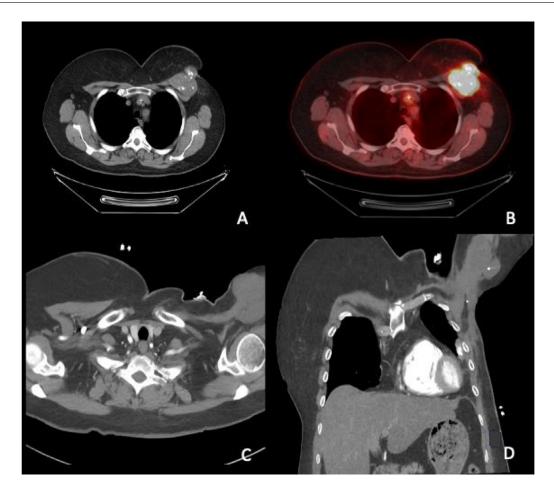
Initial staging PET/CT with upper outer MBC and subsequent CT chest with recurrent left axillary MBC after mastectomy. Initial staging PET/CT in the axial plane demonstrates avid FDG uptake of the upper outer left breast mass with tissue diagnosis of MBC (A, B). Five months after left mastectomy, CT chest with contrast in the axial (C) and coronal (D) planes demonstrates a new large soft tissue mass in the left axilla suspicious for recurrent MBC.
